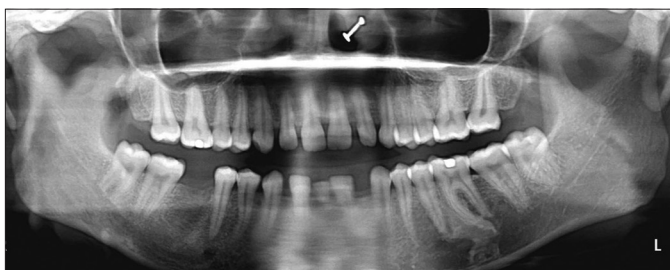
Orthopantomogram of the patient reveals absence of central incisors and the presence of retained deciduous mandibular incisor.
